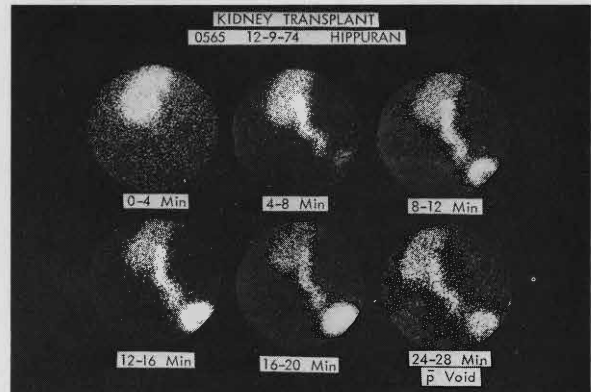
Transplant scintigraphic study four days post-transplant with good function.
